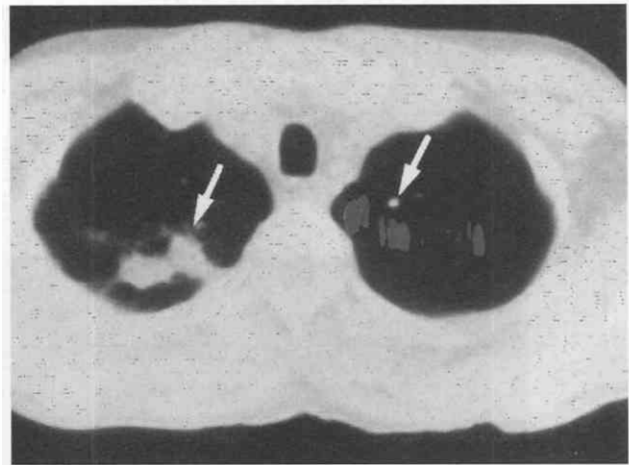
A and B, Aspergillomas, growing in old tuberculous cavities, are identified on CT.
